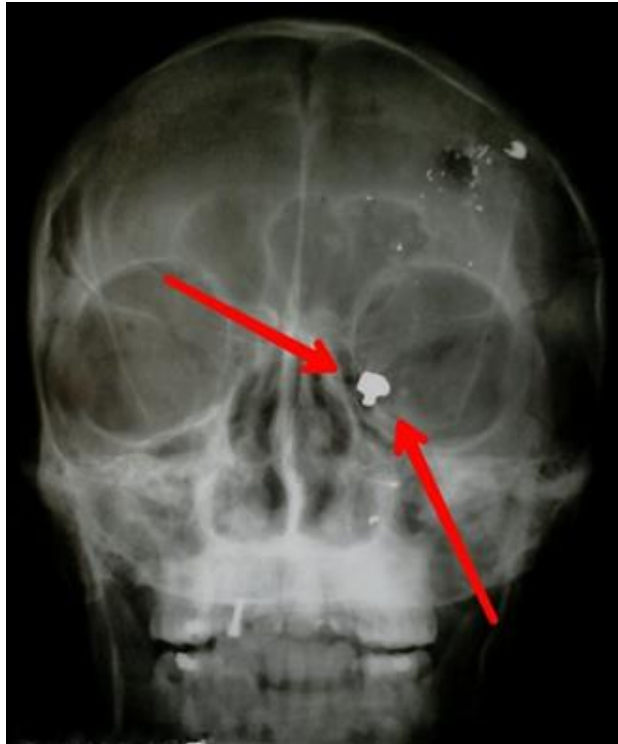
X-ray of the skull. It shows a foreign body of metallic density (PAF) in the inner wall of the left orbit, anterior floor; note the presence of metal density splints in the calotte and upper left maxilla.
